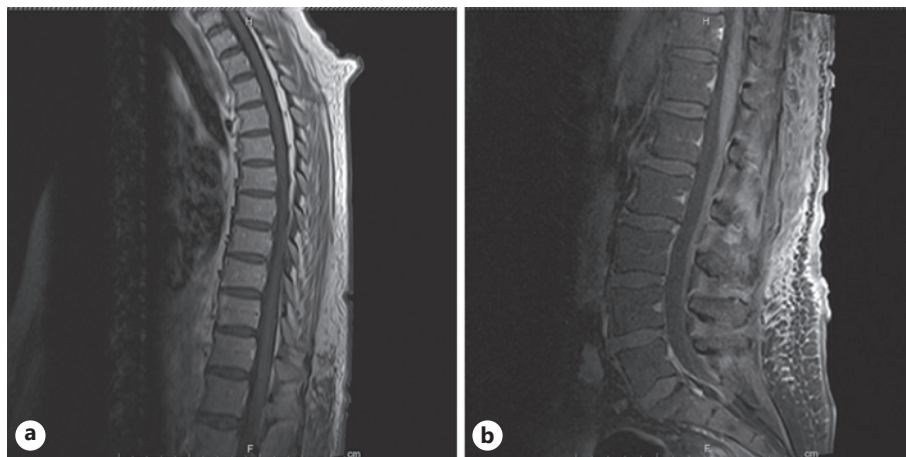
a Sagittal view of the thoracic spine on MRI showing no abnormal enhancements or cord canal compression. b Sagittal view of the lumbar spine on MRI showing the same findings.
